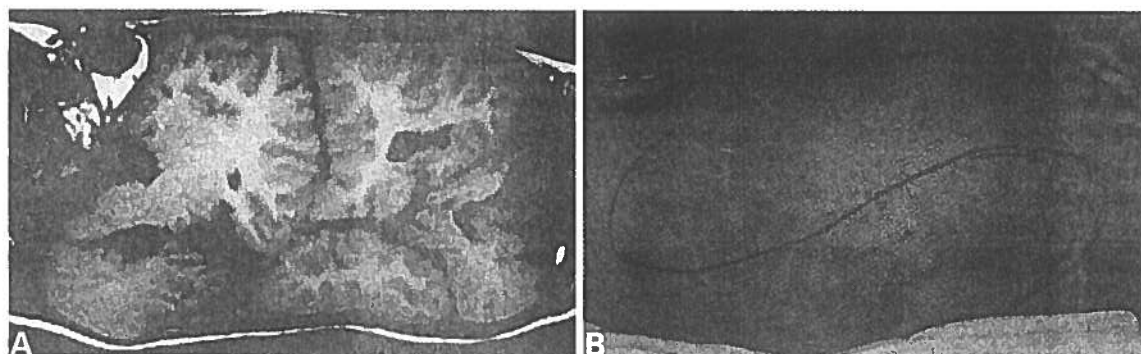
Vertically conjoined craniopagus twins: (A) preoperative CT scan; and (B) preoperative markings on the twins' head; note the scars in the temporo-occipital region resulting from the removal of tissue expanders.
